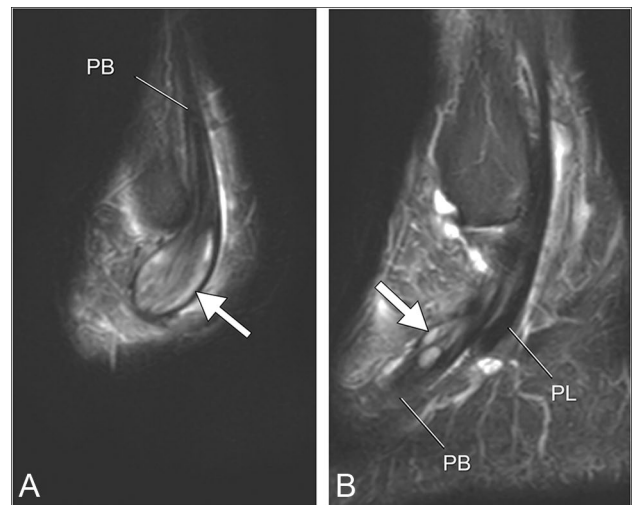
Mucoïd degeneration with intratendinous ganglion cyst formation in a 46-year-old man. Sagittal STIR MR images (A, B, lateral to medial) demonstrate mucoïd changes within the peroneus brevis tendon (PB) with “shallot-like” enlargement of the tendon (arrow, A) proximally to the inferior peroneal retinaculum and smaller intratendinous ganglion cysts distally to the retinaculum (arrow, B). PL, peroneus longus tendon
